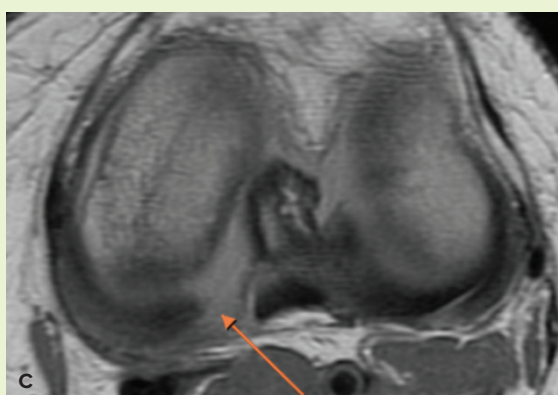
MRI images of the four radiographic findings in root tears: (A) vertical defect at root, (B) meniscal extrusion of more the 3 mm, (C) root defect on axially view, and (D) ghost sign (possibly from volume averaging of defect and meniscal edge in this case)
